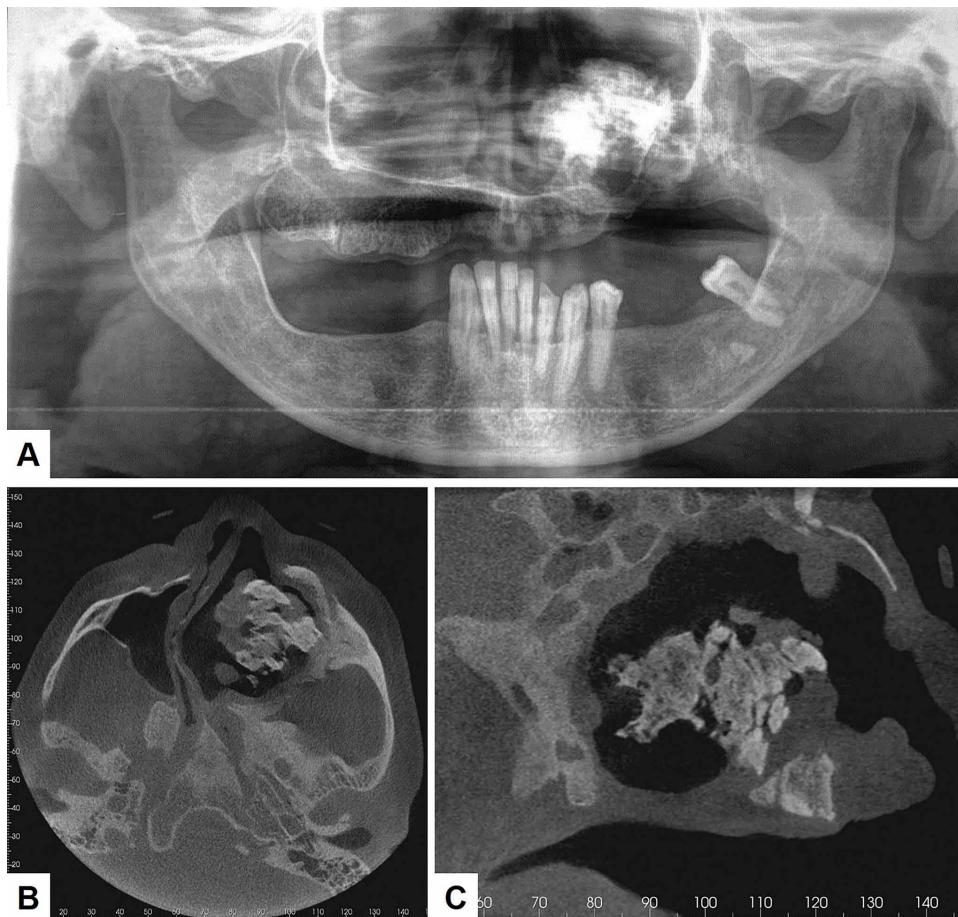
Imaging. A: Panoramic radiograph showed a mixed lesion with radiopaque predominance in the left maxillary sinus region, as well as discontinuity of the left upper alveolar ridge. B, C: Cone beam computed tomography showed a large hyperdense image inside the left maxillary sinus, with density of calcified material, presenting areas of soft tissue density within and around the hyperdense mass. The lesion extends medially with displacement of the nasal septum to the right. Extensive discontinuity of the maxillary sinus floor was observed.
